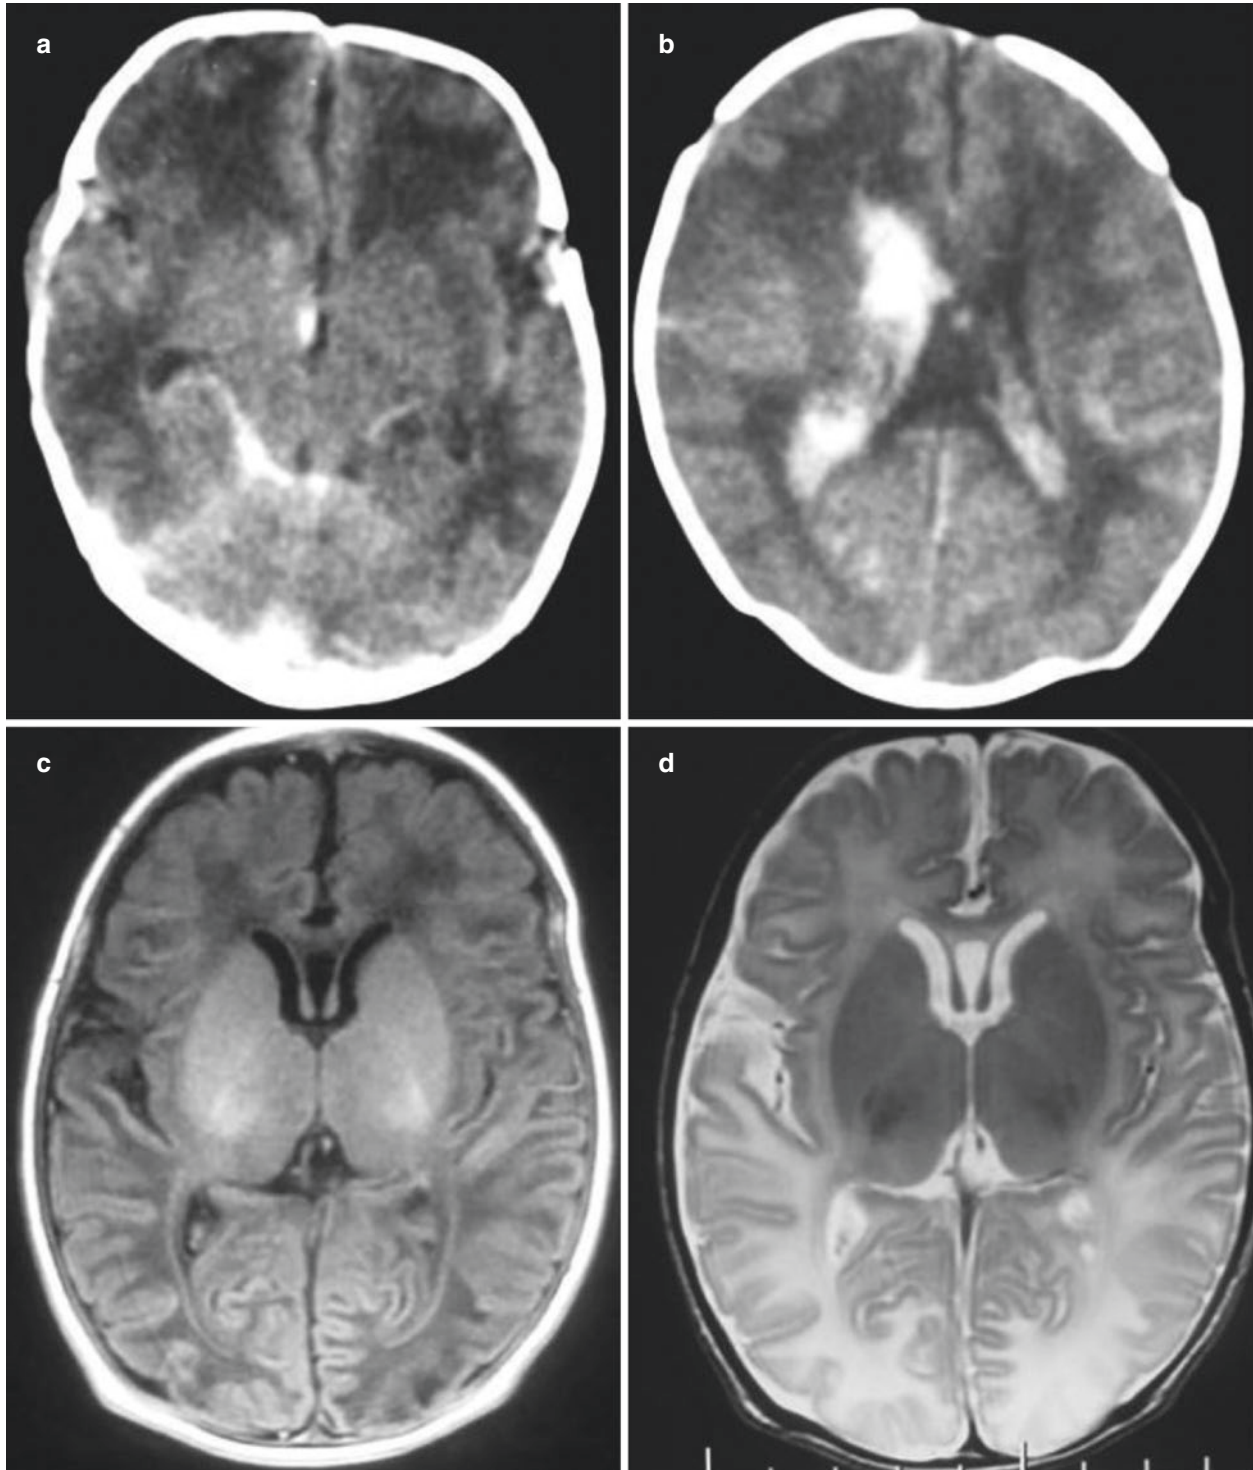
CT and MRI findings of HIE. (a, b). CT shows intraventricular hemorrhage and subarachnoid hemorrhage. (c, d). MRI manifestations of the acute phase, a wide area of brain edema
